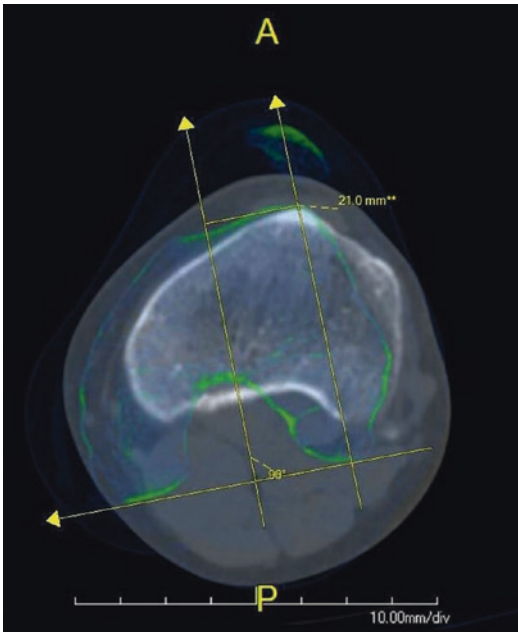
Superimposed axial CT scan images demonstrating proper measurement technique and elevated tibial tubercle to trochlear groove distance
